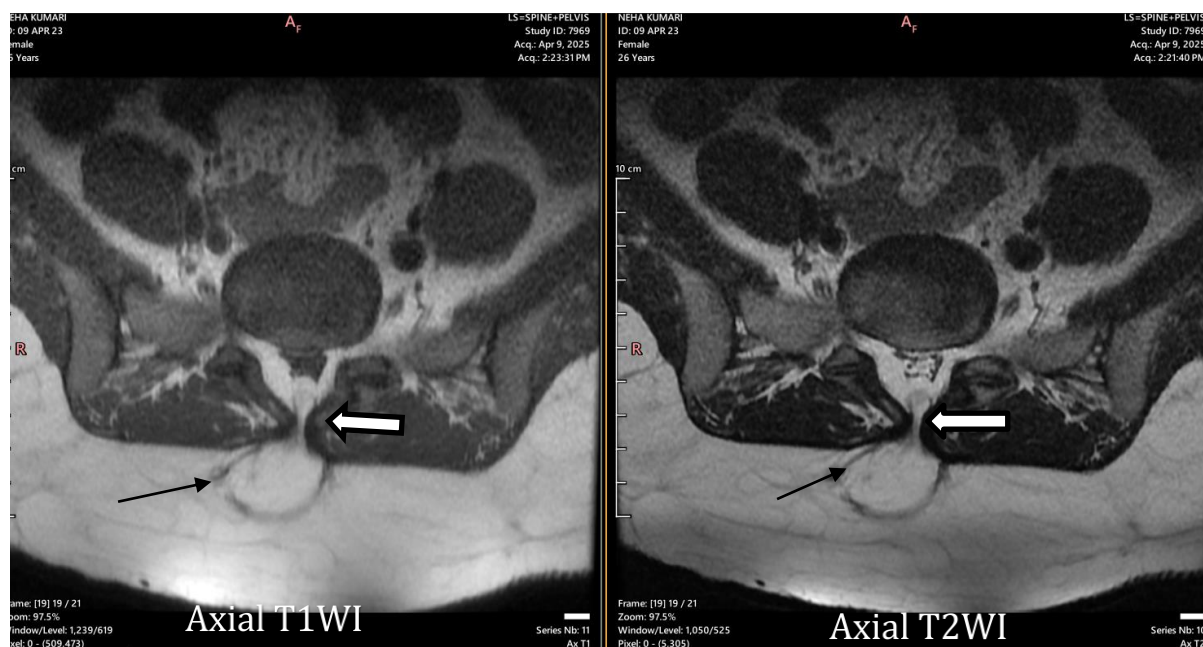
Axial T1 and T2-weighted MRI
